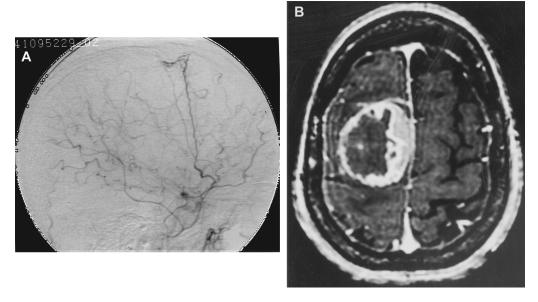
(A) Lateral external carotid injection of middle meningeal artery supplying tumor. (B) Preoperative T_1 -weighted MRI with contrast (for image-guided system) showing dramatic effect of embolization on central blood supply to tumor. Persistent medial enhancement is due to supply from falcine artery originating off the anterior ethmoid arteries, not suitable for embolization.
